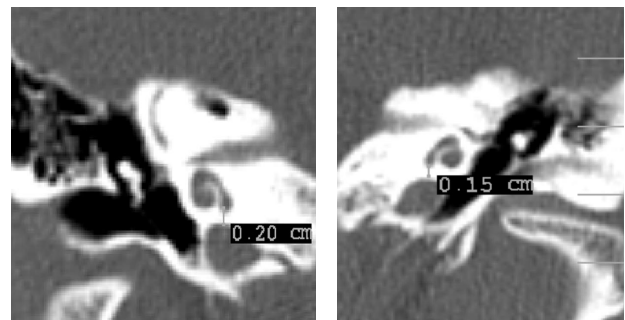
a and b: Coronal HRCT of temporal bone in a patient whose CCI measurement differ by 0.5mm between both sides [a] (RT =2.0mm), [b](LT =1.5mm)
